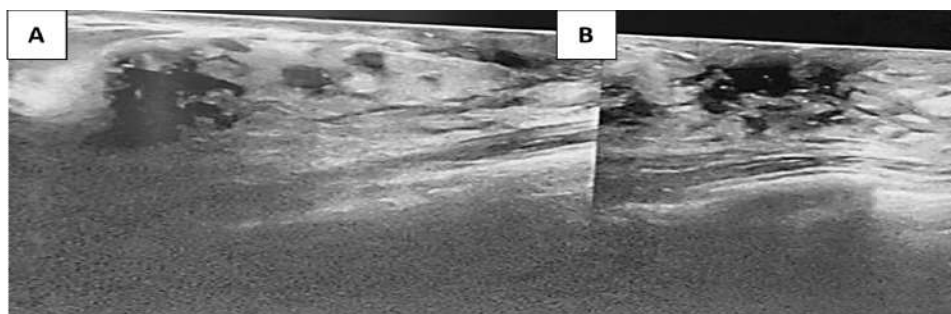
Sonography of the synchronous breast cancer in figure 1. A) Right breast showing thick edematous skin with more than one hypoechoic area associated with retroareolar architecture distortion and UOQ ductal dilatation; B) Left breast showing two irregular outline hypoechoic area associated with architectural distortion.
